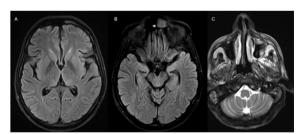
Brain MRI after treatment. (A) (B) Axial 2D T2W FLAIR and (C) axial 2D T2 TSE showing almost complete resolution of the hyperintense areas 2 weeks after treatment.
